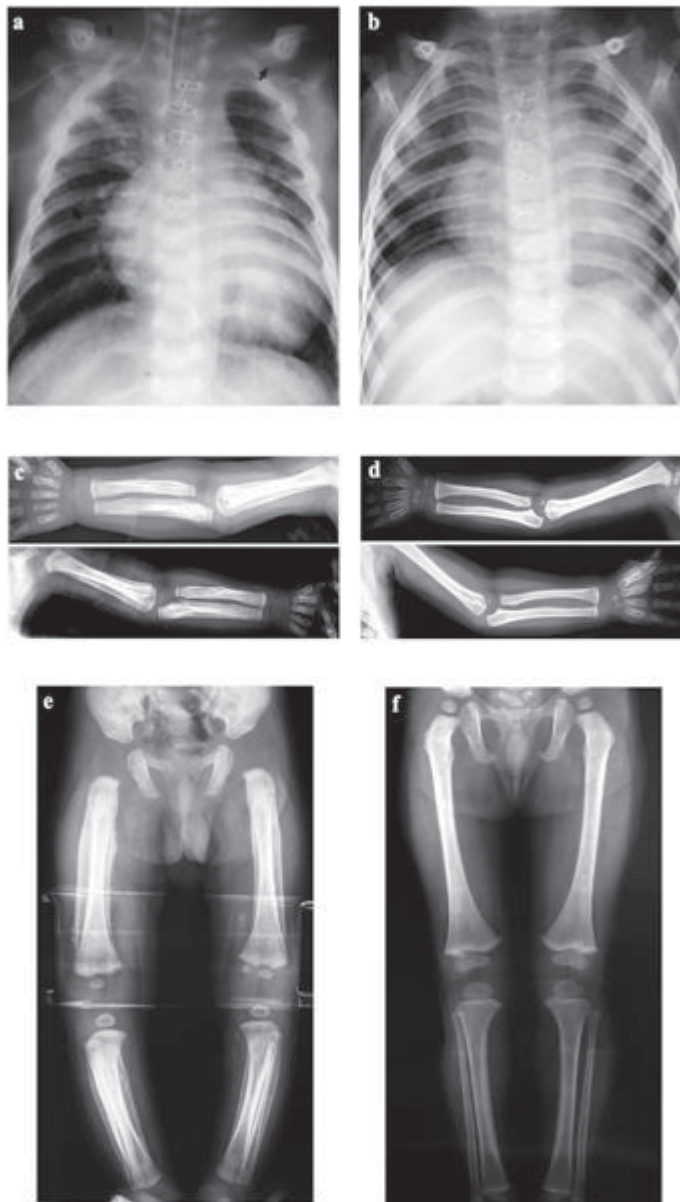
Radiological features of the patient. Radiographs of the patient showing cortical thickening of (a) the clavicles and ribs (arrows) (c) the upper extremities (e) the lower extremities. After 15 months, the X-ray findings revealed (b) normal clavicles and ribs (d, f) decreased cortical thickening of all four extremities.
